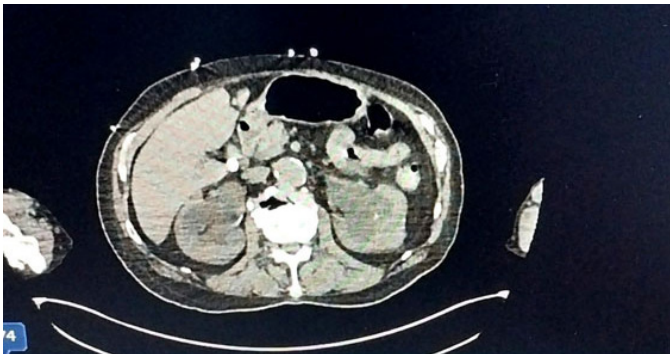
CT abdomen and pelvis showing bilateral hydronephrosis.
